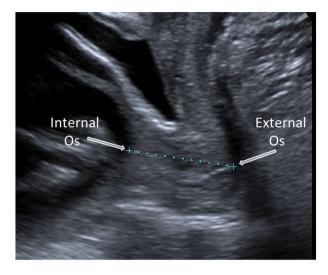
Transperineal ultrasound cervical length.
